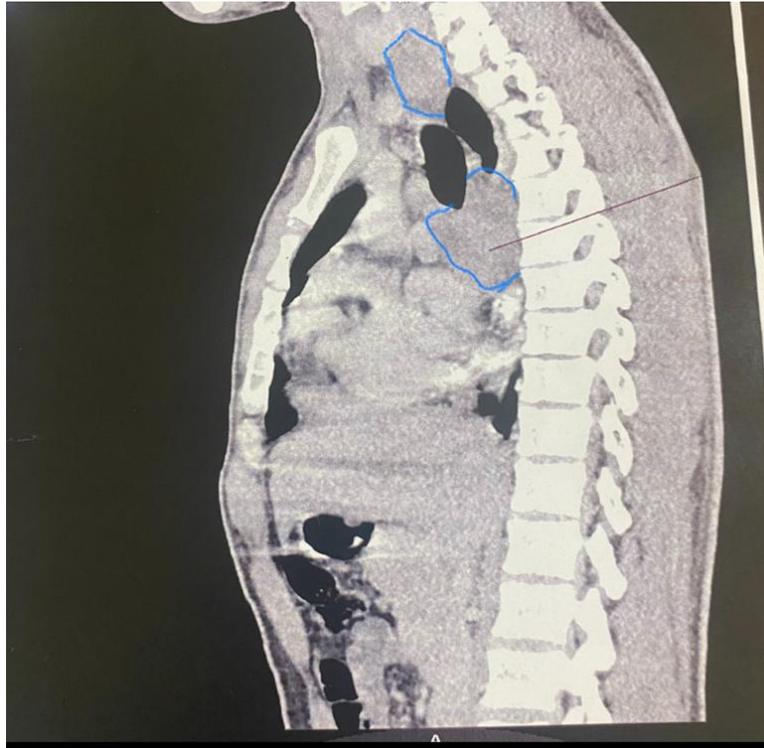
Frontal image chest CT scan of the abdomen of the patient demonstrating revealing the presence of two masses:
